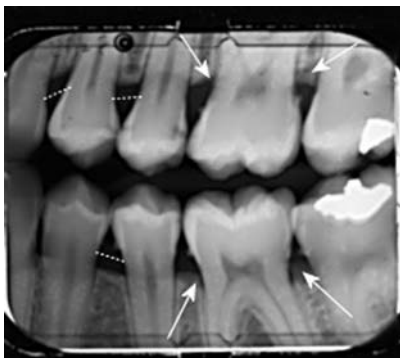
Early Evidence of Alveolar Bone Loss. The crestal bone on this radiograph demonstrates triangulation, a pointed, triangular appearance that indicates a widening of the periodontal ligament space due to bone loss.
